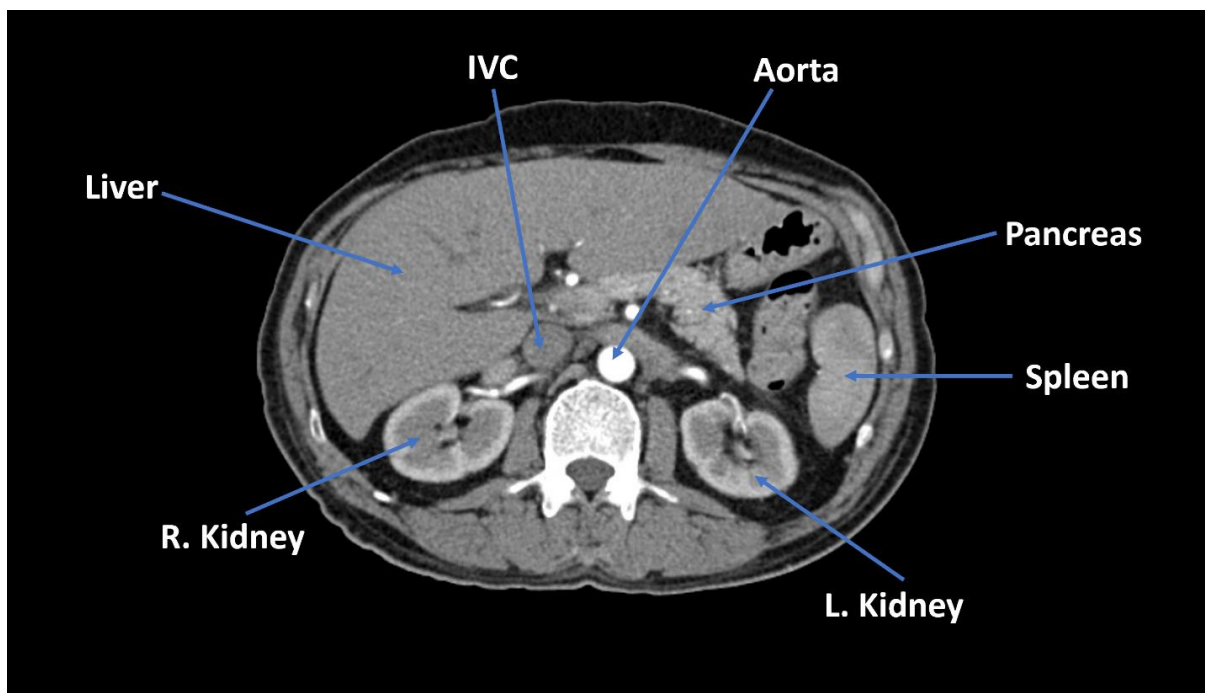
Normal liver CT
